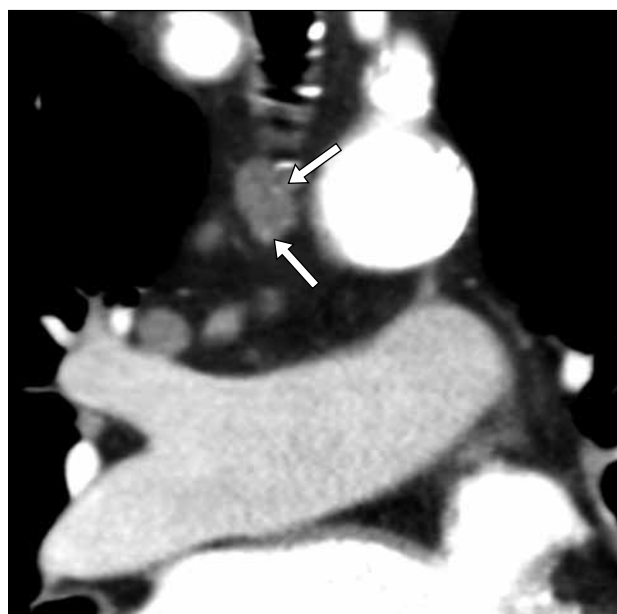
This is a case of an 81-year-old male with bronchial cancer. Chest computed tomography (multislice computed tomography 64 x 0.75-mm slice collimation, tube voltage 120 kV, frontal reconstruction) shows a moderately enlarged paratracheal lymph node in the ATS region 4R (11 x 18 mm) and subtle hyperdensities—like calcifications (arrows) which are polycyclic in shape.
